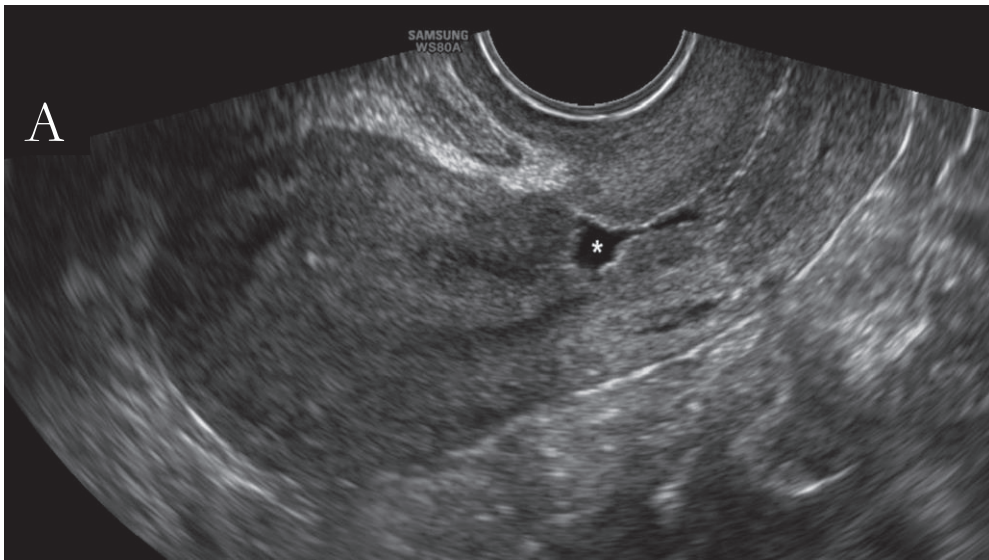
A) Triangular-shaped isthmocele in a woman with one previous Cesarean delivery detected by means of transvaginal ultrasonography (asterisk). B) After saline administration in sonohysterography the shape and size of the isthmocele remain. The hyperechoic tip of the catheter is visible left of the asterisk
